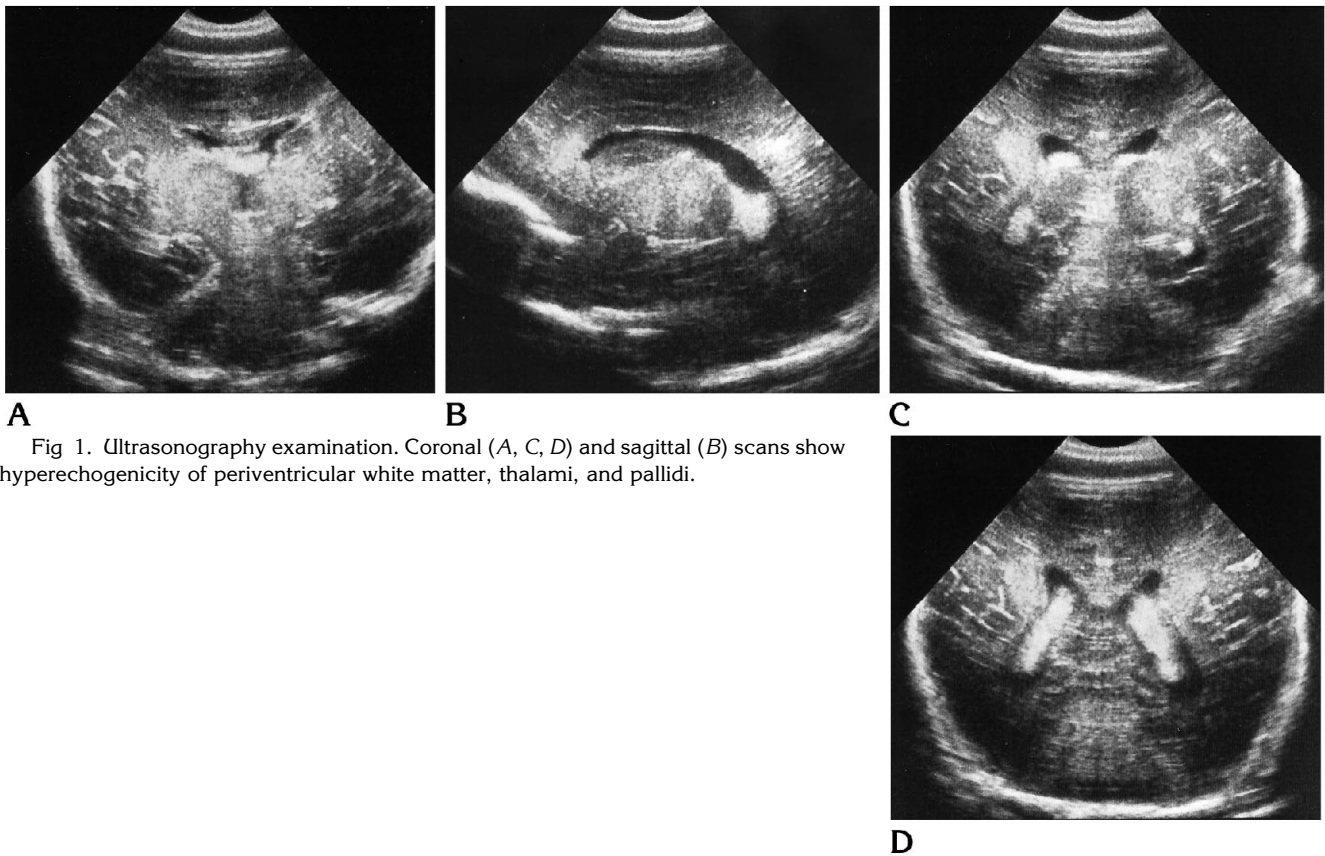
Ultrasonography examination. Coronal (A, C, D) and sagittal (B) scans show hyperechogenicity of periventricular white matter, thalami, and pallidi.
